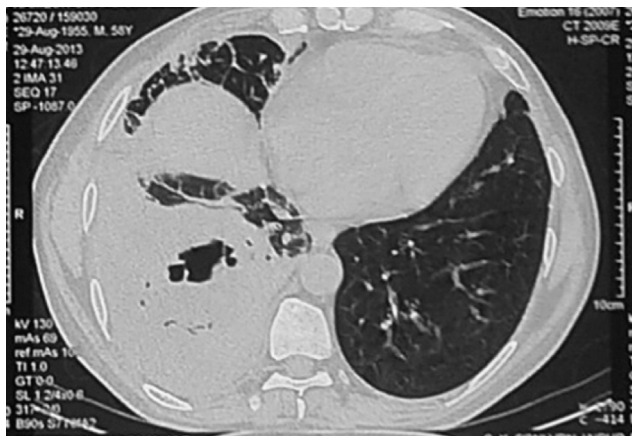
CT showing collapse consolidation in right lower lobe with cavitation in the apical segment.
